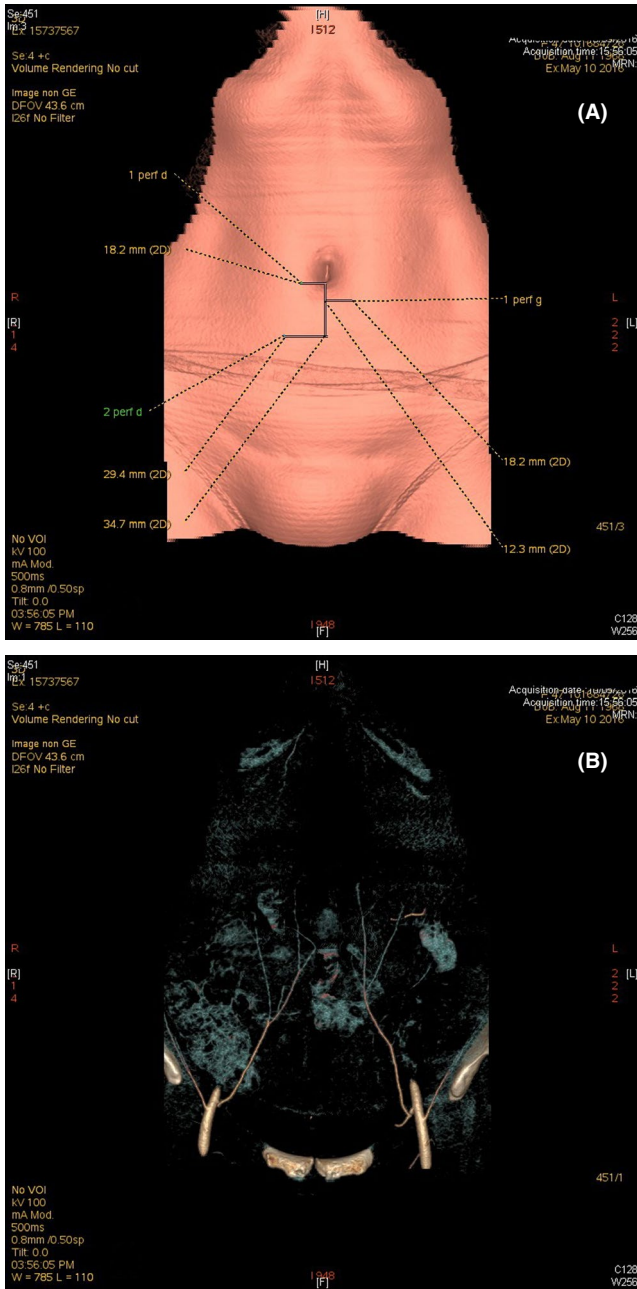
CT angiography of the deep inferior epigastric artery (A). A CT scan of the vascular network (B)
